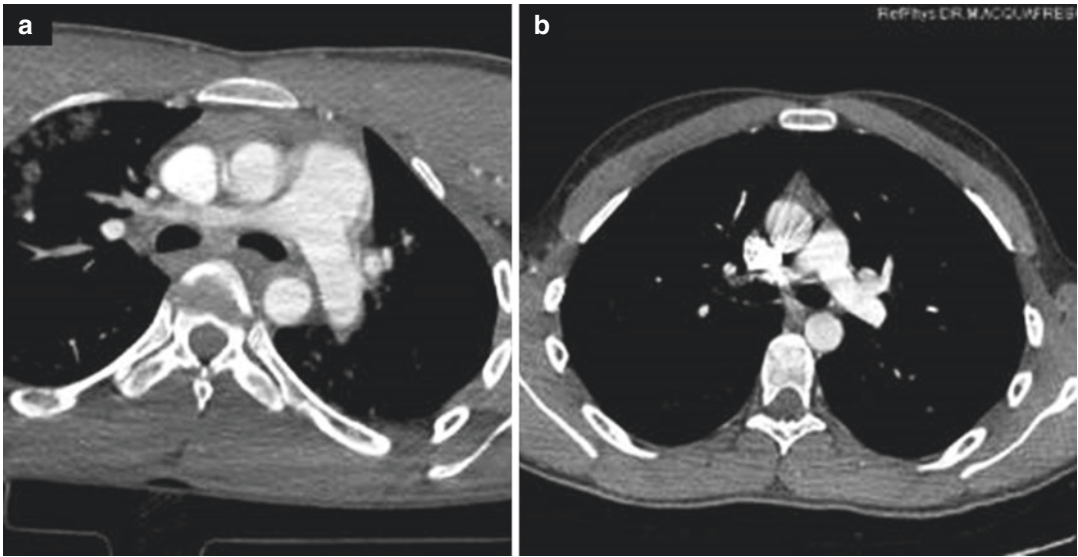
Artifact. (a) Axial CT image shows motion artifact at the aortic ascendans. (b) Axial CT image shows dense contrast media in the superior vena cava
